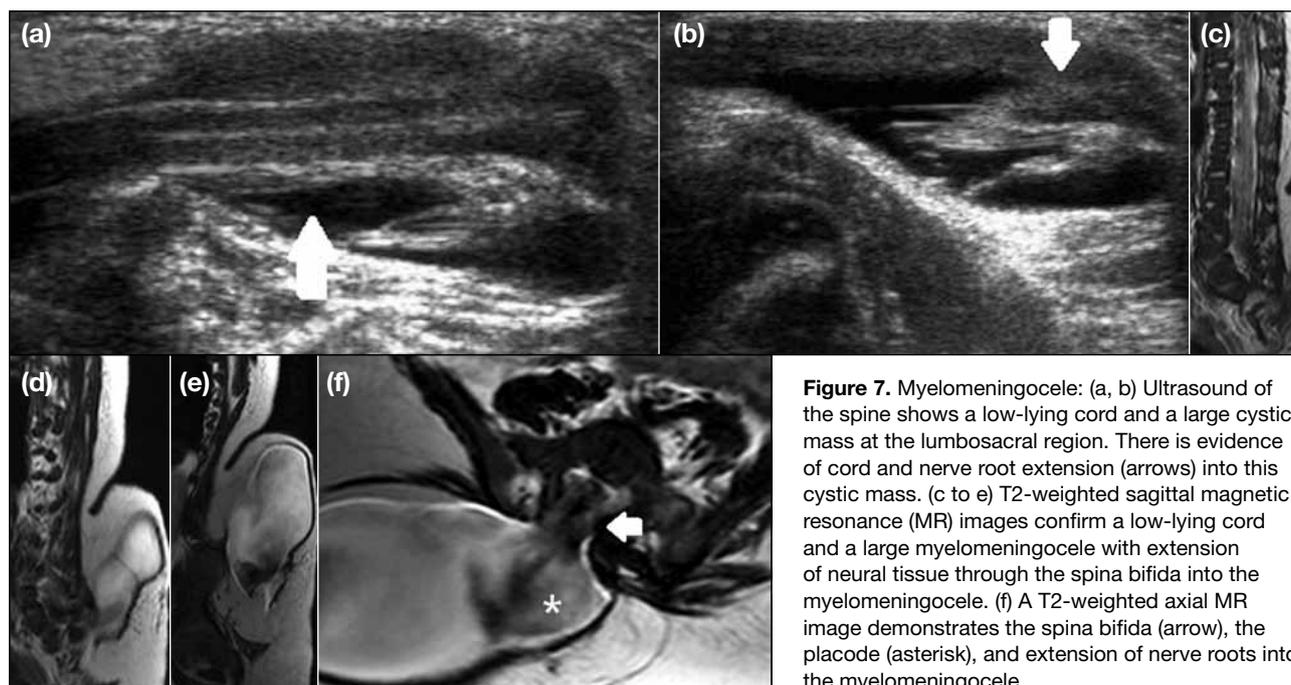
Myelomeningocele: (a, b) Ultrasound of the spine shows a low-lying cord and a large cystic mass at the lumbosacral region. There is evidence of cord and nerve root extension (arrows) into this cystic mass. (c to e) T2-weighted sagittal magnetic resonance (MR) images confirm a low-lying cord and a large myelomeningocele with extension of neural tissue through the spina bifida into the myelomeningocele. (f) A T2-weighted axial MR image demonstrates the spina bifida (arrow), the placode (asterisk), and extension of nerve roots into the myelomeningocele.
